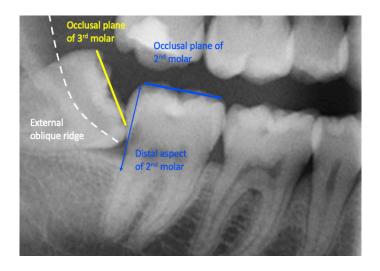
The various anatomical points required for the assessment of third-molar partial emergence/eruption, indicated on a panoramic radiograph
